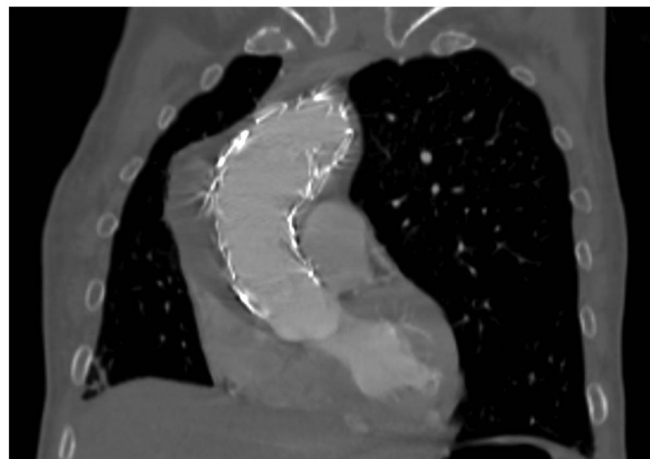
Six month follow-up computed tomography angiogram (CTA).
